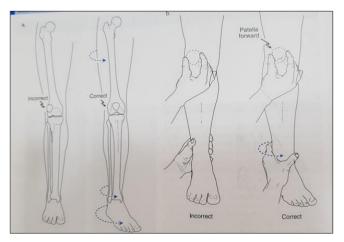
Ideal position of patella before taking x-ray
